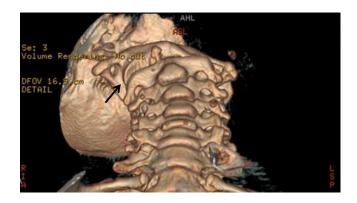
3D Reconstructive CT showing the anterior cervical spine with the atlas (C1) rotated on the axis (C2). The left lateral mass is posteriorly displaced (white arrow) and the right lateral mass is anteriorly displaced (black arrow) indicating atlantoaxial rotatory subluxation.
